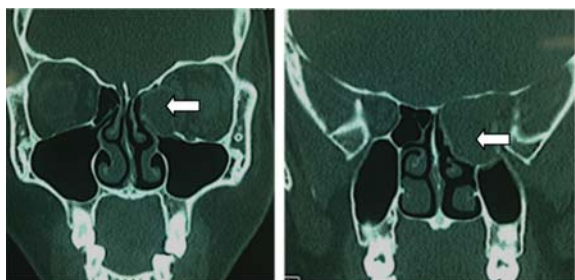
CT paranasal sinus: homogenous cyst-like lesion involve ethmoidal area.
